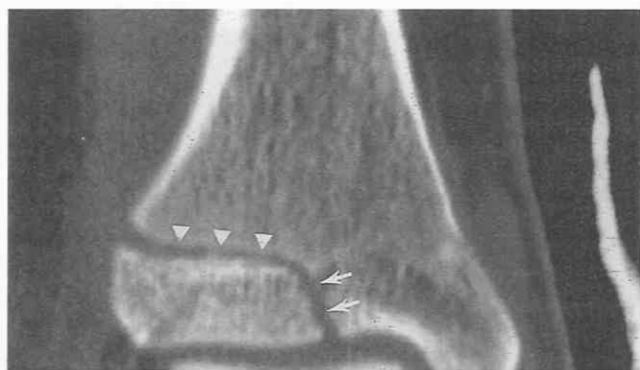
A juvenile Tillaux fracture of the distal tibia in a 14-year-old boy. Coronal CT reformat image delineates the transverse fracture line through the lateral growth plate (arrowheads) and the sagittal fracture line through the epiphysis (arrow). The width and alignment of the fracture at the articular surface can be well visualized.
